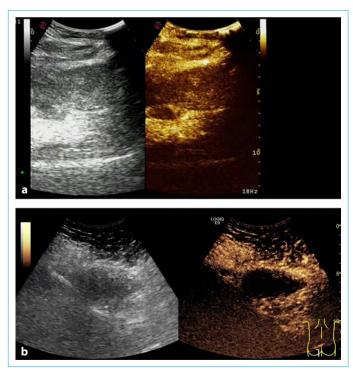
Contrast-enhanced ultrasound (CEUS). (a) 2 months after drug therapy. (b) 26 months after drug therapy. No abnormal perfusion foci were found.
